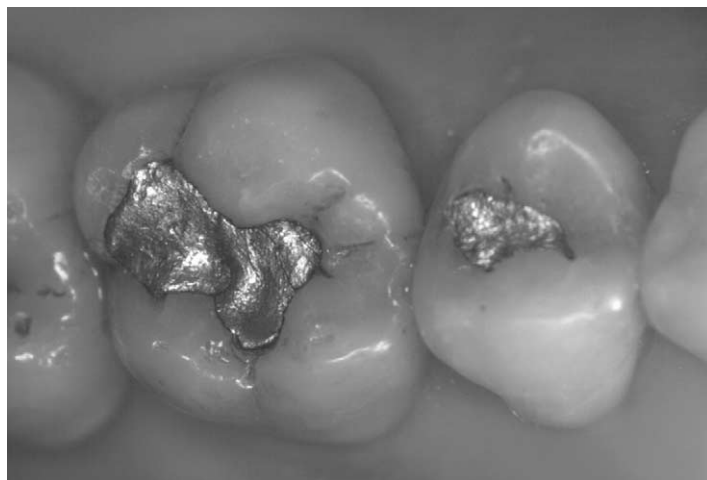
Preoperative view of an upper second bicuspid and first molar with two amalgam restorations with insufficient margins. A bitewing radiograph reveals carious lesions in the distal proximal area of the premolar and at the mesial proximal surface of the molar.
